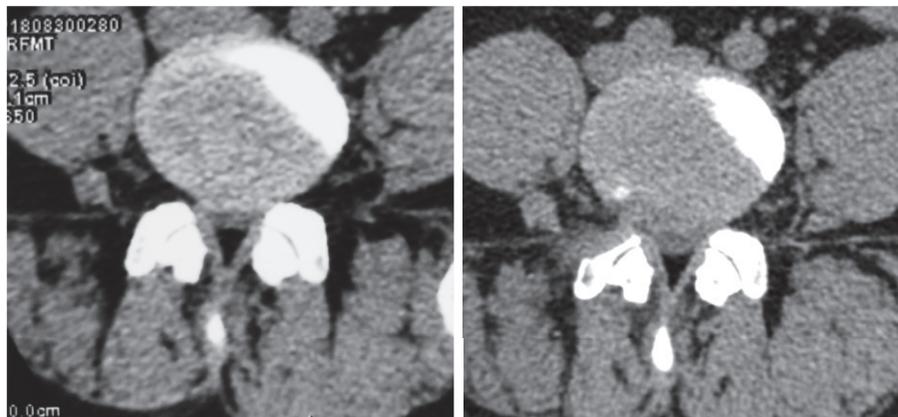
Compared to the preoperative CT scan (Panel A), the herniated disc to the right side was totally removed at the postoperative CT scan (Panel B). Notably, the hypertrophic SAP at the right side was partially removed.
